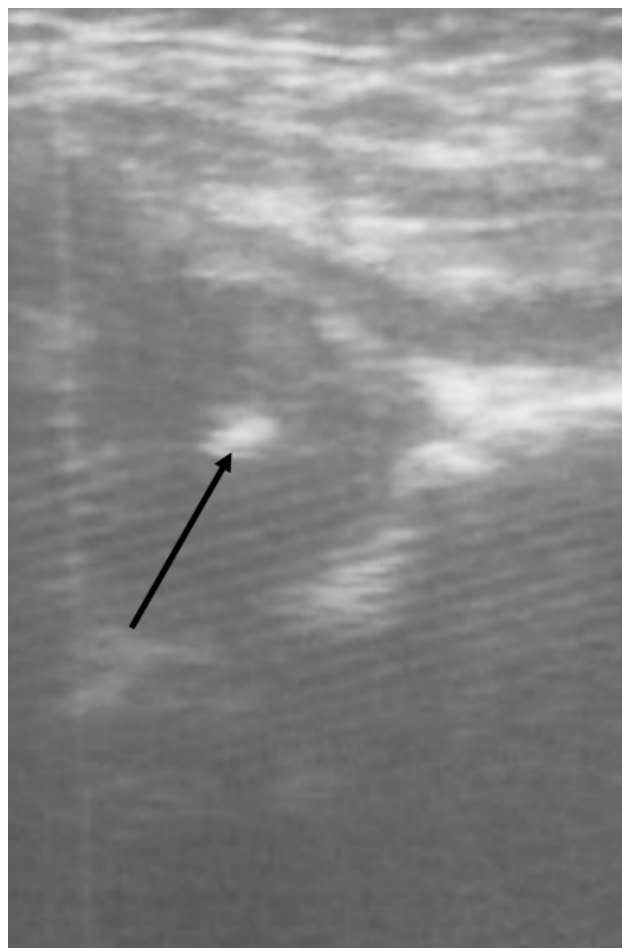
Ultrasound image of the unchanged hip joint of a child of three months of life.
